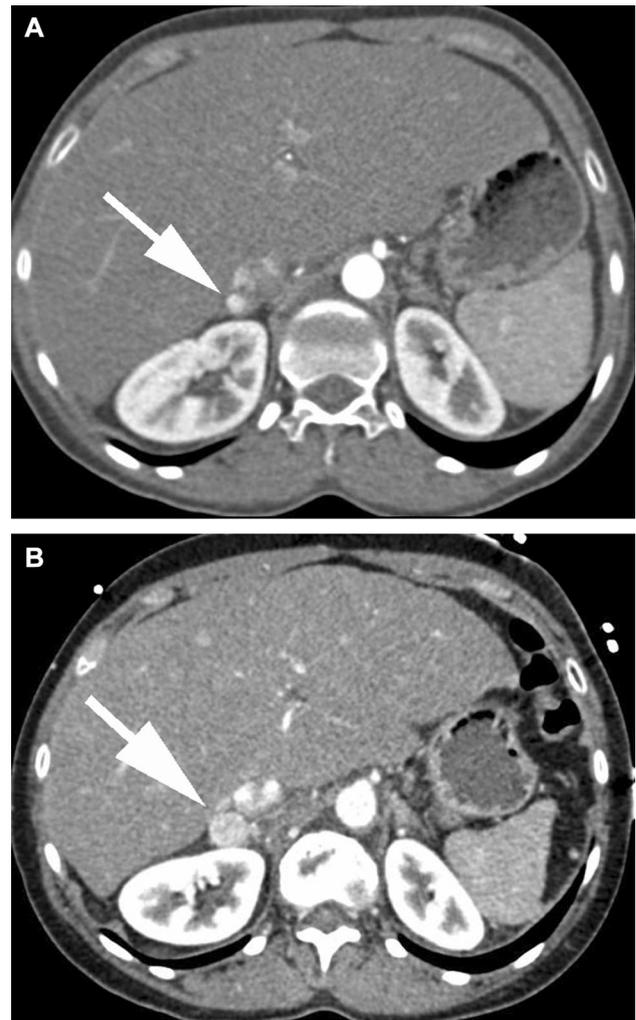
28-year-old woman presented with shortness of breath, and pulmonary CTA demonstrates a hypervascular right adrenal nodule measuring 0.7 cm and 236 HU (a). Subsequent pulmonary CTA performed 7 years later reveals enlargement of the nodule to 1.6 × 1.4 cm (b), which enhanced to 145 HU arterial phase and 127 HU venous phase on dedicated adrenal CT for suspicion of pheochromocytoma. Urinary metanephrines were elevated to 3011 mcg/24 h (normal range 115–695 mcg/24 h). Right adrenalectomy confirmed a 2.2 cm pheochromocytoma
